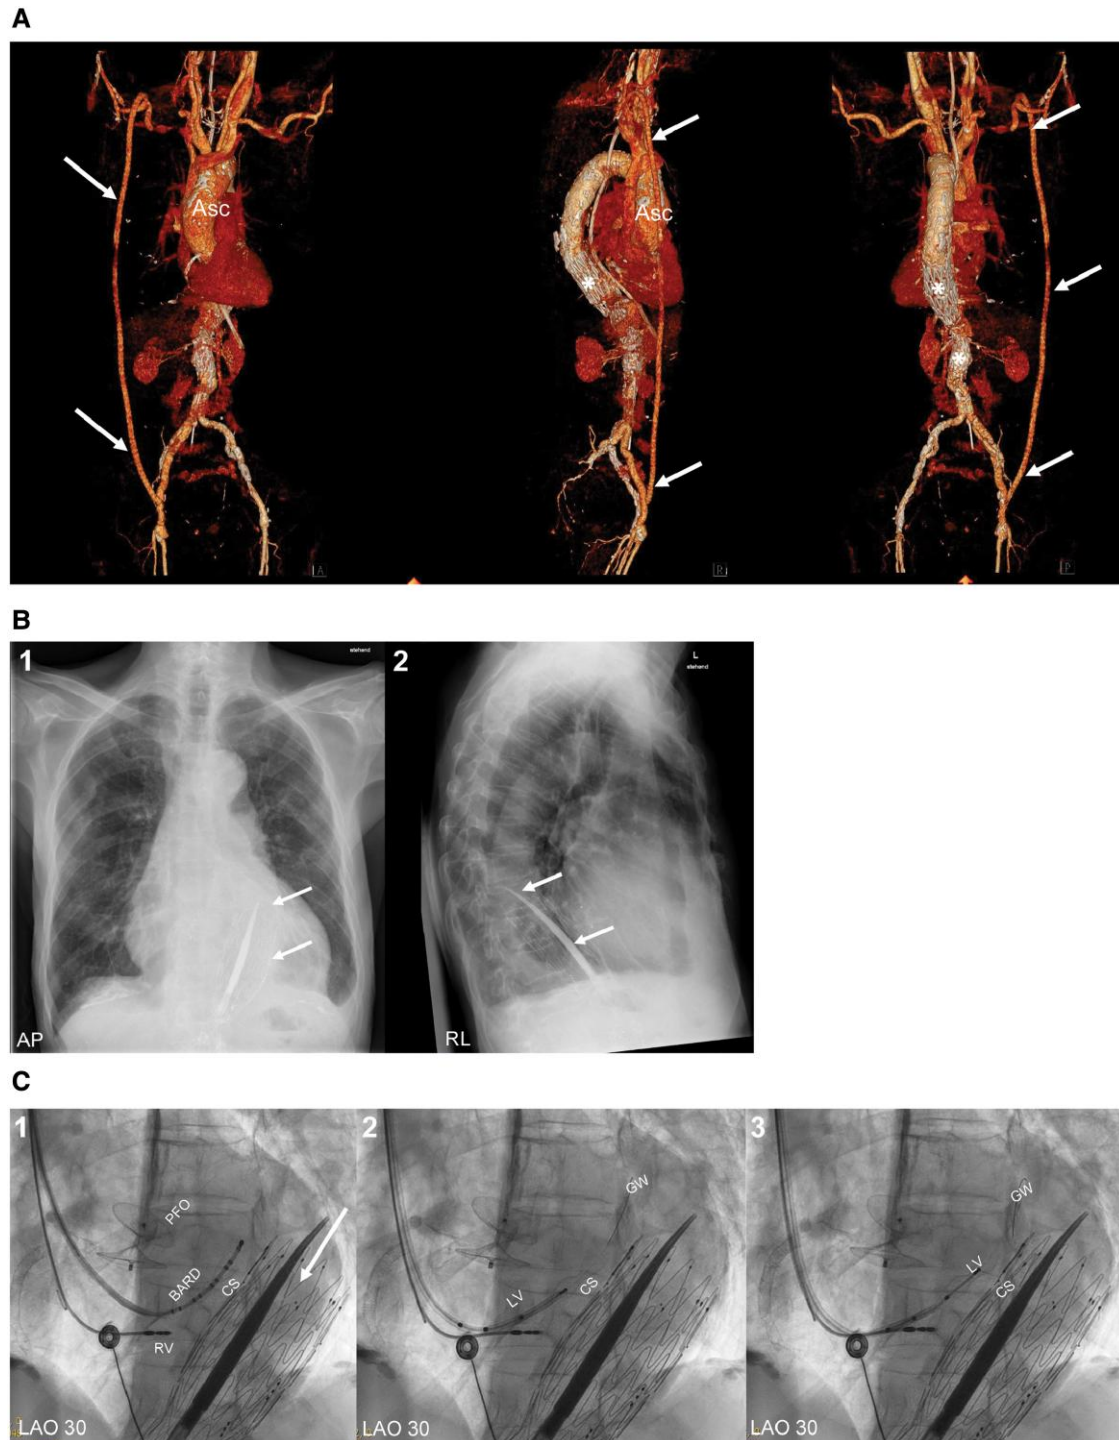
(A) Computed tomography showing the aneurismatic dilated aorta ascendens (Asc), bypass via a right subclavian vein to a femoralis communis (arrows), and proximal and distal parts of the non-fully expanded intra-aortic stent in the abdominal aorta (*). (B) Chest radiograph before CRT implantation showing the abandoned intra-aortic stent with the trapped introducer tools (arrow). (C) (1) Cannulating the CS with the steerable catheter (BARD), PFO occluder (PFO), abandoned intra-aortic stent (arrow) passing the CSR (CS), and RV lead (RV). (2) The LV lead (LV) is still in the IS located in front of the CSR, and the guidewire (GW) placed in the main coronary sinus. (3) Advancing the LV lead through the CSR. (D) Guidewire (GW) advanced into the target vein (posterolateral), with the LV lead being pushed over the guidewire into the final posterolateral position—marked with arrows (1 and 2). (E) Final result, atrial lead (RA) located antero-laterally, right ventricular lead (RV) inferoseptally/apically and left ventricular lead (LV) through the CSR (CS) within the posterolateral side branch of the CS together; PFO occluder marked with *, a stented right coronary artery and the abandoned aortic stent with the introducer marked with an arrow. CS, coronary sinus; CSR, coronary sinus reducer; IS, introducer sheath; LV, left ventricular lead; PFO, patent foramen ovale; RV, right ventricular lead.
